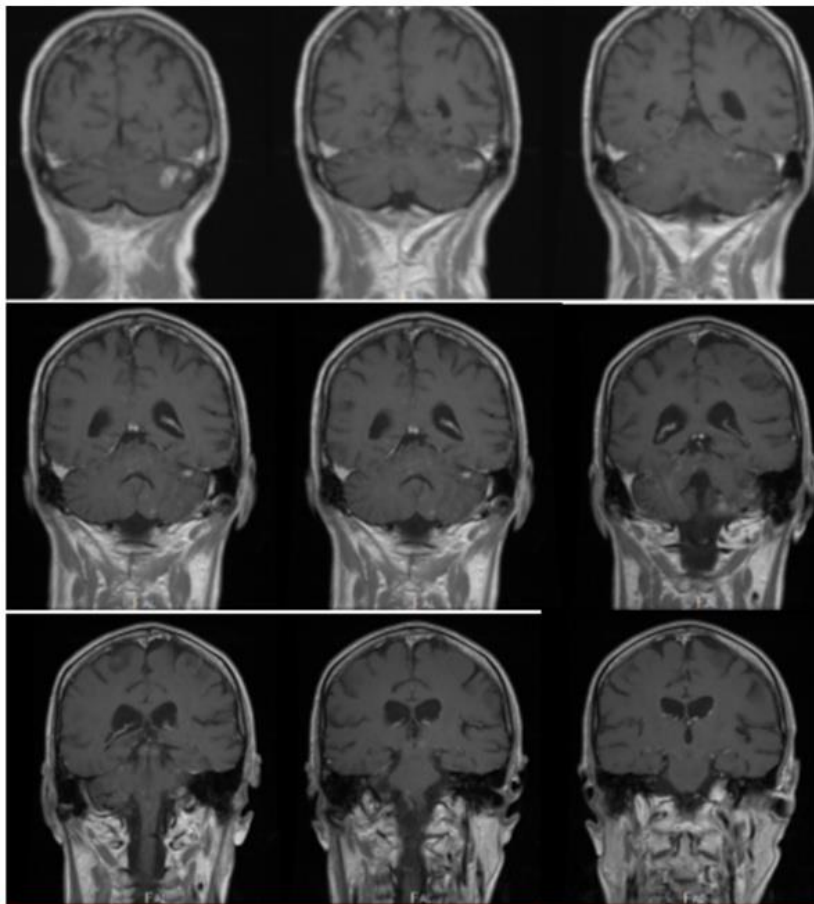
COR T1 FLAIR+C MR postcontrast images after 4 months of RT and after 3 months of targeted therapy alone
